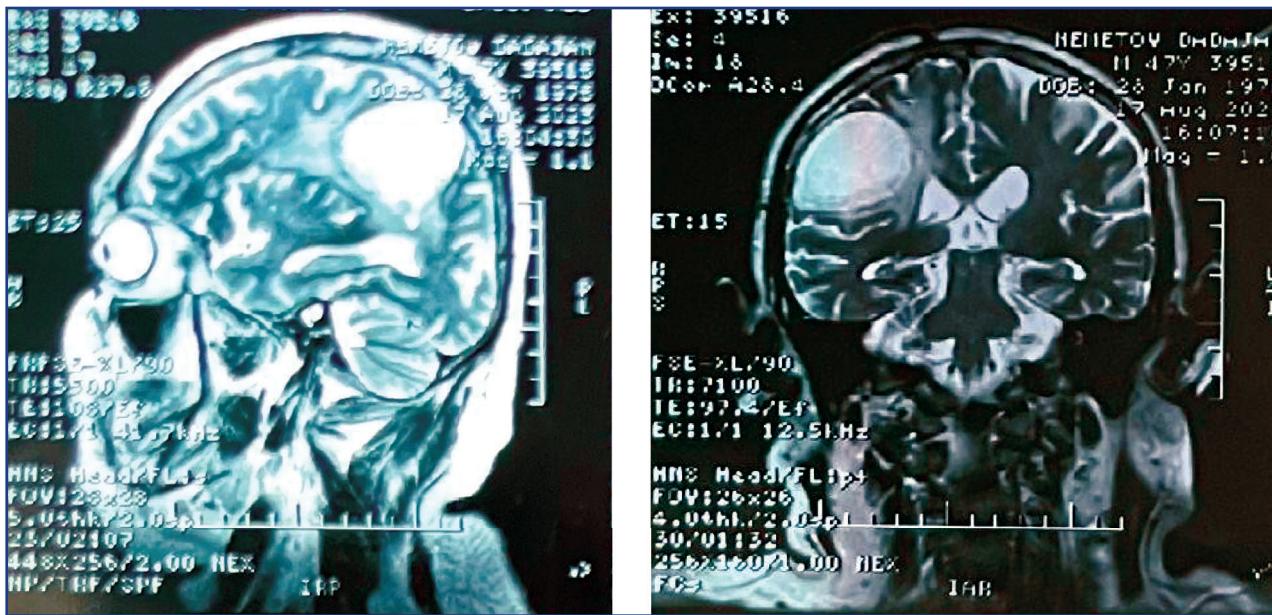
MRI data from February 2023: a soft mass in the right parietal region, perilesional edema, and ventricular compression were determined.
